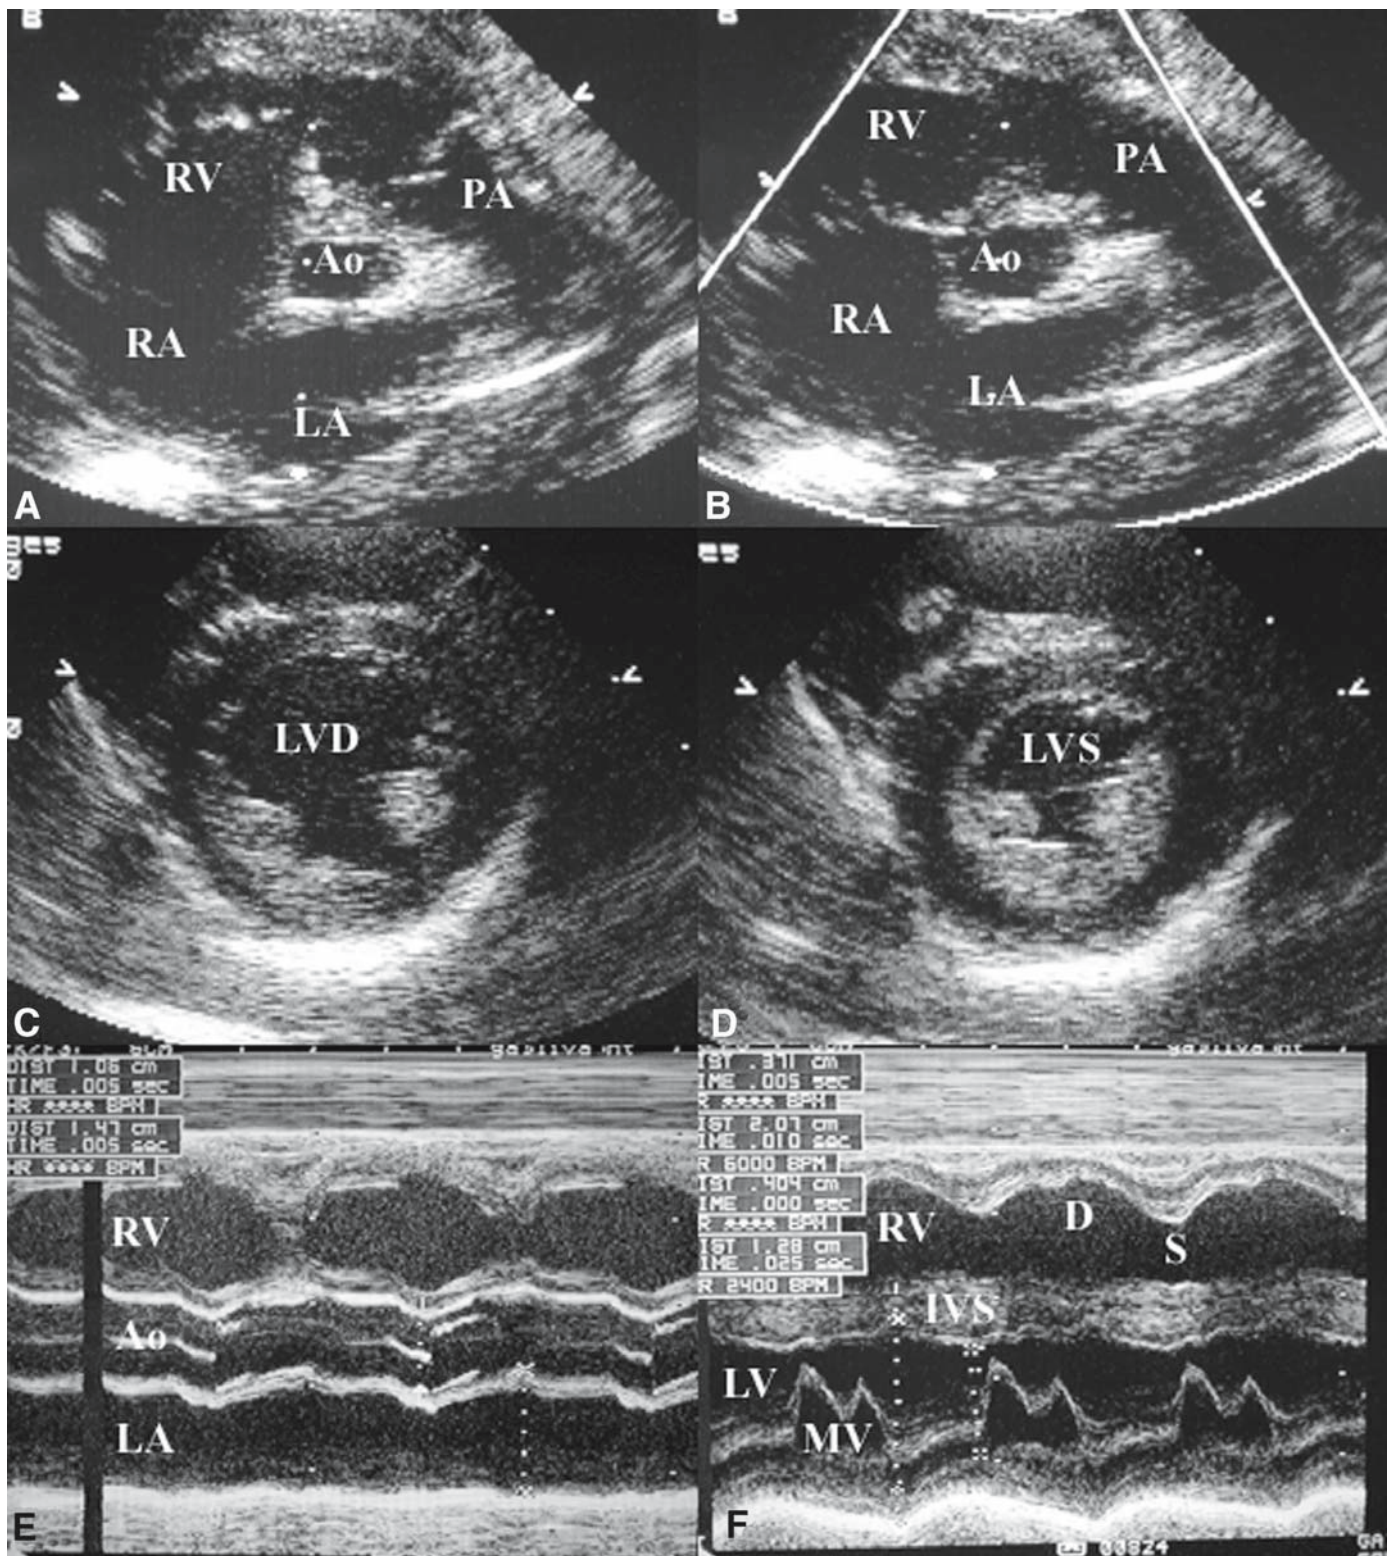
Two-dimensional and motion-mode (M-mode) images obtained from parasternal short-axis views. (A) View through the base of the heart in diastole. (B) Same imaging plane in systole with the pulmonary valve open. M-mode measurements of the right ventricle, aorta, and left atrium (E) are obtained in this plane. (C) Cross-sectional or short-axis view of left ventricle at the level of the papillary muscles in diastole. (D) Same plane in systole. This is the appropriate level for quantification of left ventricular function by shortening fraction. (F) M-mode recording at the level of the mitral valve, a plane just above that seen in C and D. Abnormalities of mitral valve motion can be demonstrated in this plane. Ao, aorta; D, diastole; IVS, = interventricular septum; LA, left atrium; LV, left ventricle; LV, left ventricle, diastole; LVS, left ventricle, systole; PA, main pulmonary artery; RA, right atrium; RV, right ventricle; S, systole.
